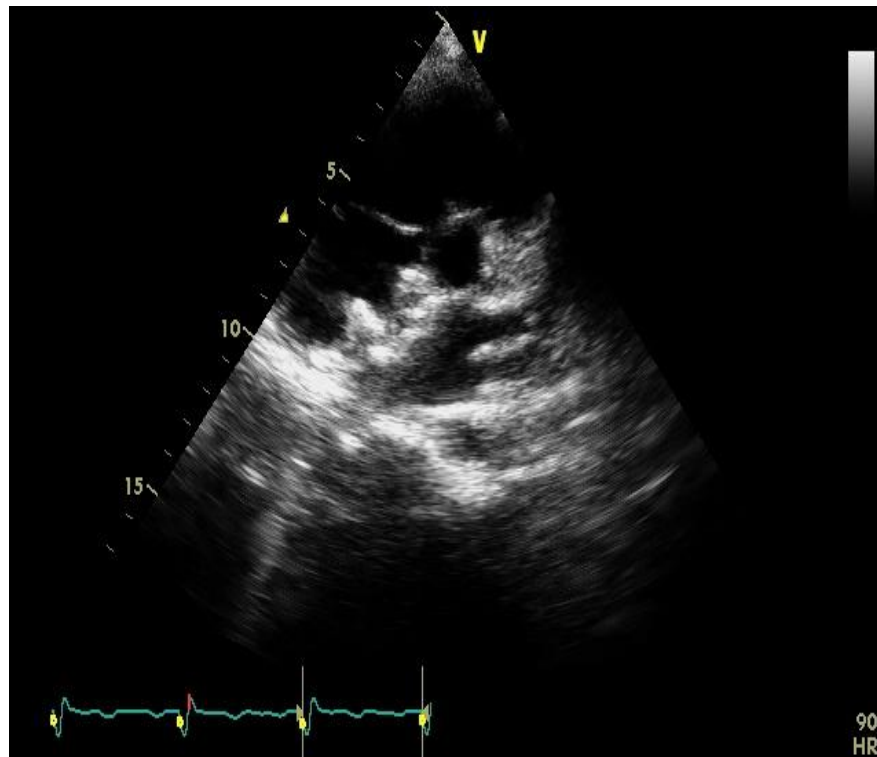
ASD device seen in parasternal short axis view
